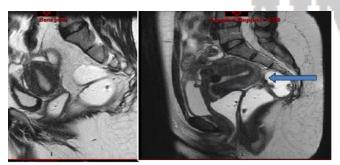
MRI sagittal T2 sequence thickening of the transitional zone: adenomyosis
